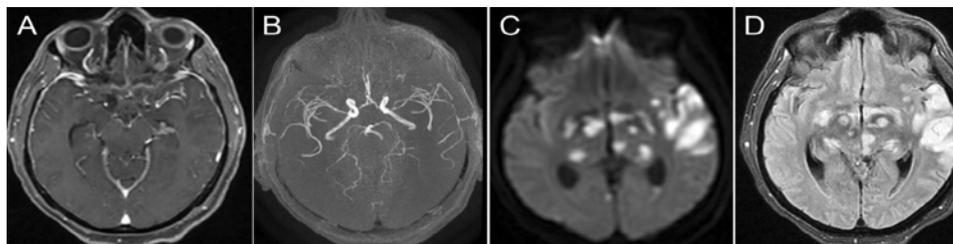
MRI performed 10-days after admission. Axial T1 weighted contrast-enhancement shows basal cisterns and frontotemporal leptomeningeal enhancement.
